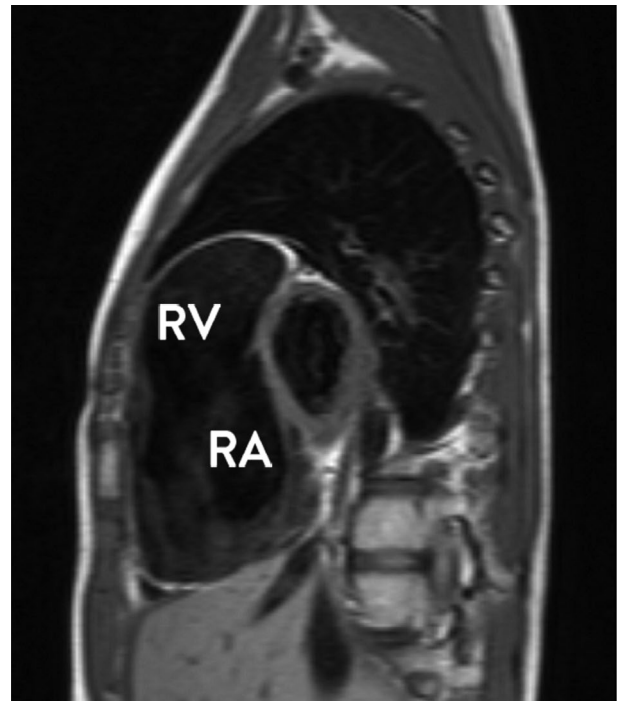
Magnetic resonance imaging showing dilatation of the right side of the heart; RA = right atrium; RV = right ventricle.
